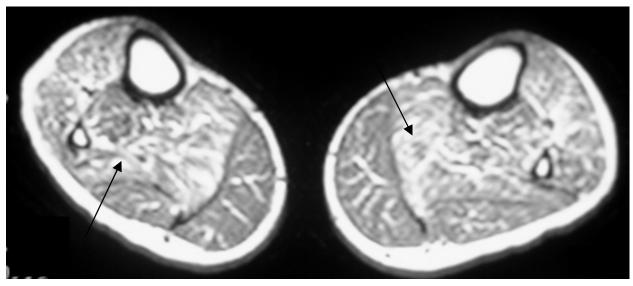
a - Case II-2. mMRI, T1-weighted images and axial sections showing fatty infiltration of muscle compartments of the anterior, posterior deep and superficial leg, with greater involvement of the anterior and deep posterior compartment.
